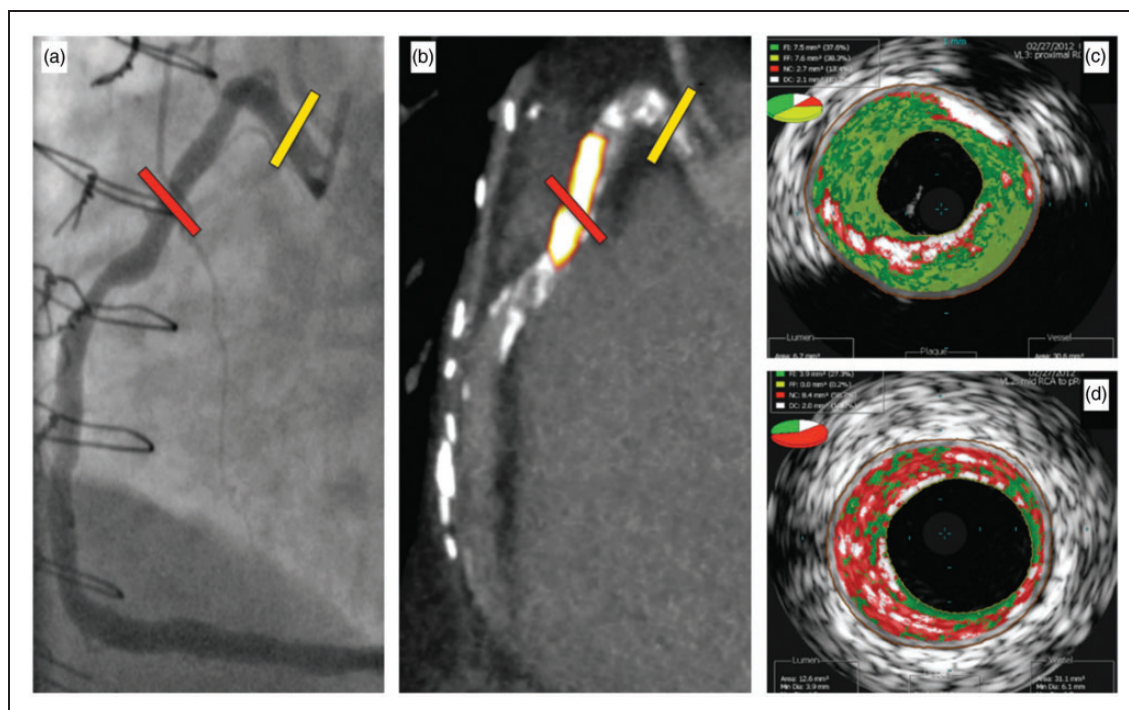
Increased ^{18}F -sodium fluoride (^{18}F -NaF) uptake in culprit coronary artery lesion. In a patient with coronary artery disease, invasive coronary angiography (a) showed non-obstructive disease in the right coronary artery. Corresponding ^{18}F -NaF positron emission tomography/computed tomography (b) showed a region of increased ^{18}F -NaF activity (positive lesion, red line) in the mid-right coronary artery (tissue-to-background ratio, 3.13) and a region without increased uptake in the proximal vessel (negative lesion, yellow line). Radiofrequency intravascular ultrasound shows that the ^{18}F -NaF negative plaque (c) is principally composed of fibrous and fibro-fatty tissue (green) with confluent calcium (white with acoustic shadow) but little evidence of necrosis. On the contrary, the ^{18}F -NaF positive plaque (d) shows high-risk features such as a large necrotic core (red) and micro-calcification (white). Adapted from Joshi et al.²² with permission.
